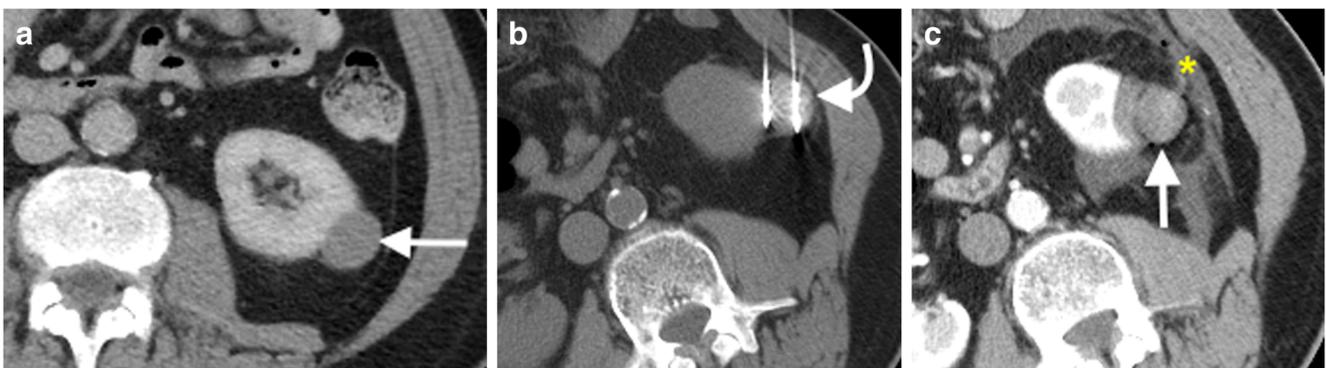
Axial enhanced CT (a) of a 71-year-old man with a 2.5-cm cT1a exophytic type I papillary RCC arising from the posterolateral left lower kidney (arrow). RENAL score: 4p. Axial unenhanced CT (b) with the patient in an oblique position after placement of 2 microwave antennas (curved arrow). Axial enhanced CT immediately following microwave
